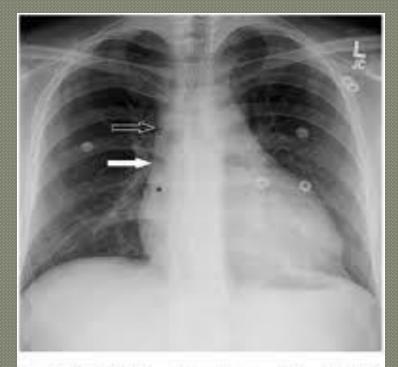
Frontal chest radiograph demonstrating the right lateral wall of the superior venn cava (open arrow) and the junction of the lower SVC with the superior conversity of the right cardiac border (SVC-RAA junction) (closed arrow). The cavoatrial junction (*) lies approximately 1-2 cm below SVC-RAA junction in adults.
